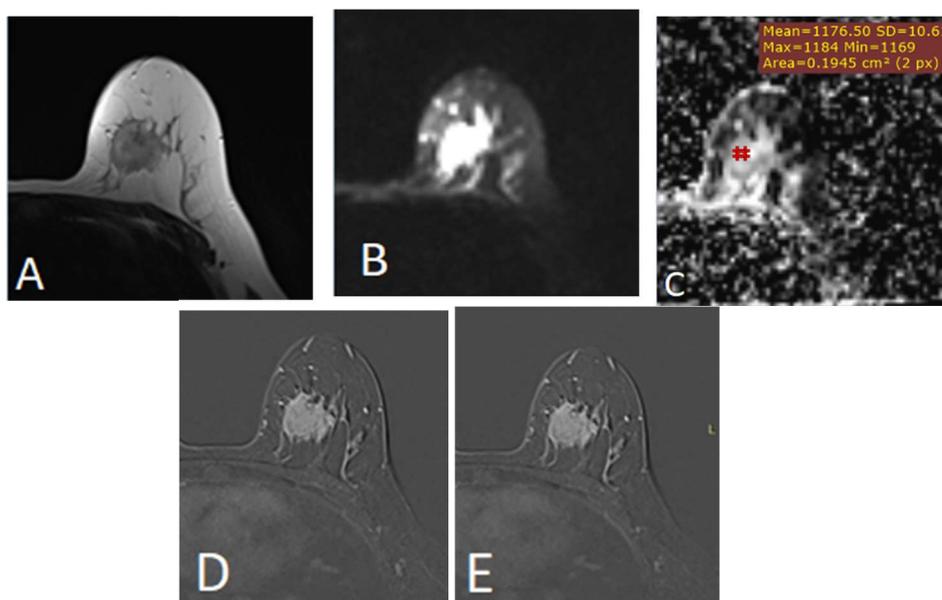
Women of 40 years old, presented with a mass in her left breast, Dynamic MRI is performed, T2 WI (A), DWI (B) ADC map (C), post contrast T1WI subtraction images early (D), and late (E). showing irregular outline speculated mass showing heterogeneous enhancement, with type III kinetic curve, restricted diffusion with ADC value of 1.1×10^3 . the lesion was assigned as BI_RADS category V, the Kaiser score given score of 11, biopsy was done, the result was (left breast lobular carcinoma).
